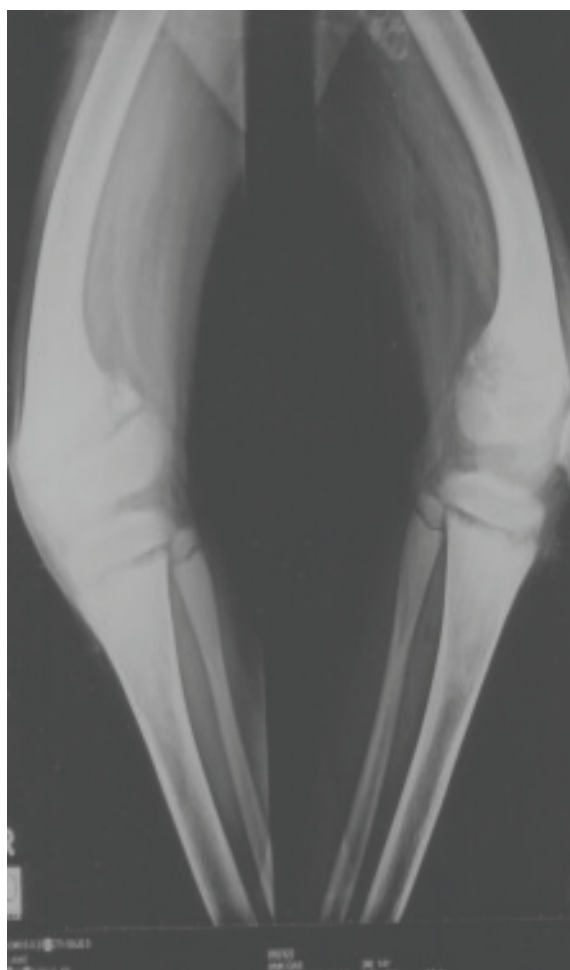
X-ray of left knee joint including lower half of femur & upper half of tibia and fibula shows metaphyseal dysplasia in the lower end of femur, both tibia and fibula. Bowing of both femur (Coxa vera) deformity noted.
